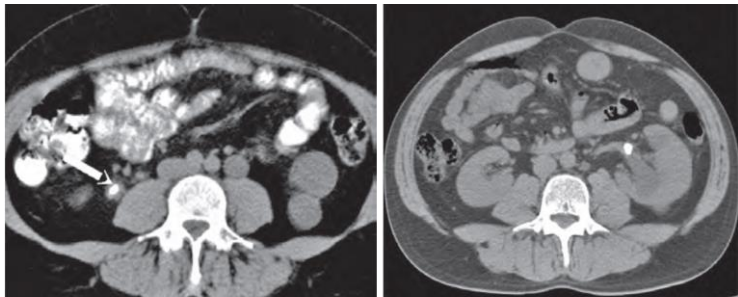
CT scan: a - stone in lower third of the right ureter b - stone in proximal part of left ureter
